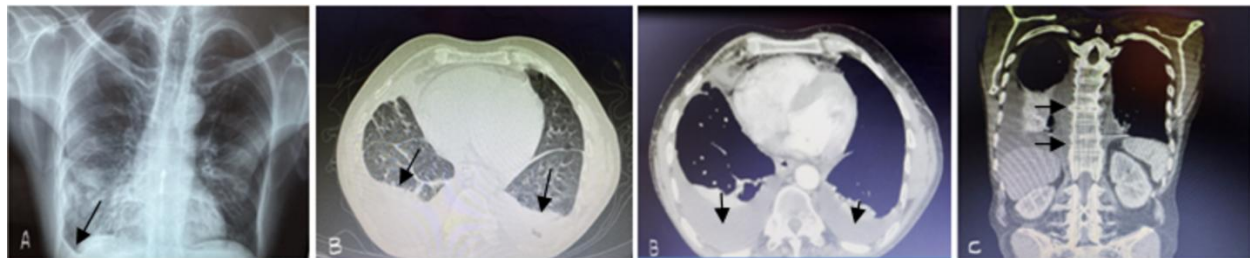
A. The chest radiograph showed small right pleural effusion. B. Computed tomography of total body showing bilateral pleural effusion and ankylosing spondylitis (C).
